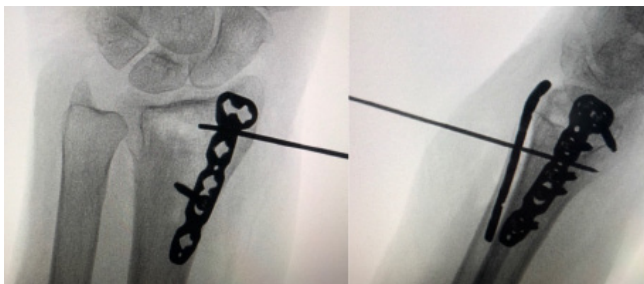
Perioperative X-ray.
